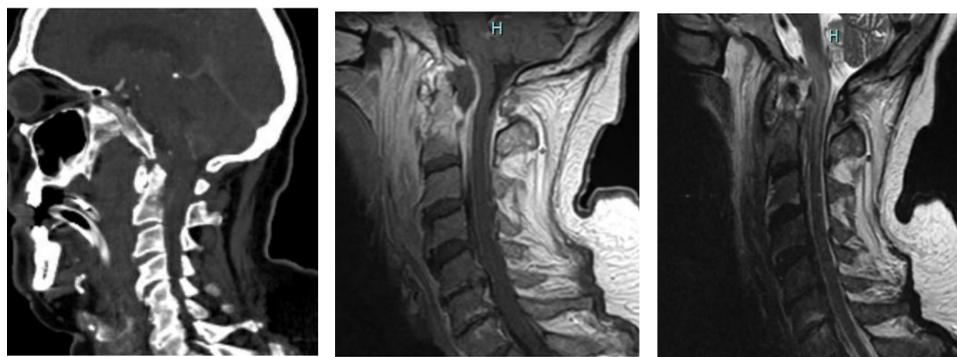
CT after Transoral approach
